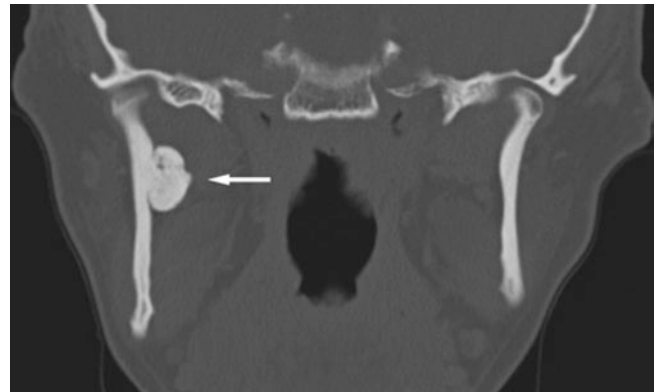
Osteoma, mandible; 93-year-old female, incidental finding. Coronal CT shows bony outgrowth (exostosis) at lower mandibular border (*arrow*)
